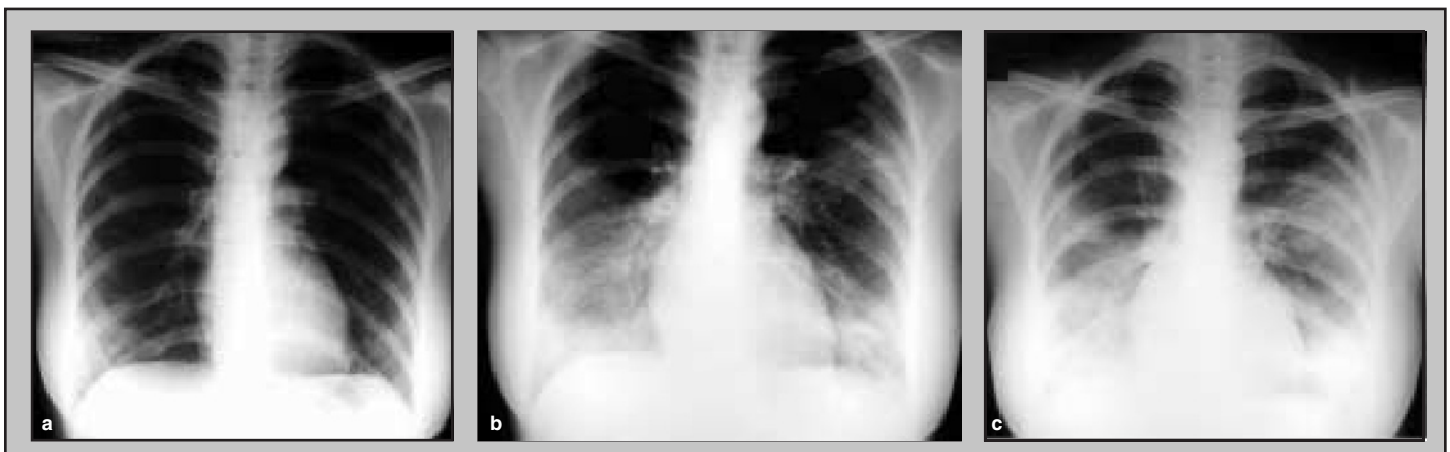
Serial chest x-ray findings in a 28-year-old woman with severe acute respiratory syndrome. The patient presented acutely 3 days after onset of a high fever, and was immediately hospitalized upon attendance at the Accident and Emergency Department. (a) Mild ground glass consolidation of the right lower lobe when the patient was relatively free of respiratory symptoms and did not require oxygen therapy on day 1; (b) overnight deterioration in clinical status with increasing oxygen requirement to 4 L/min and development of bilateral consolidation on day 2; (c) progressive respiratory failure and worsening of chest x-ray findings on day 3.
